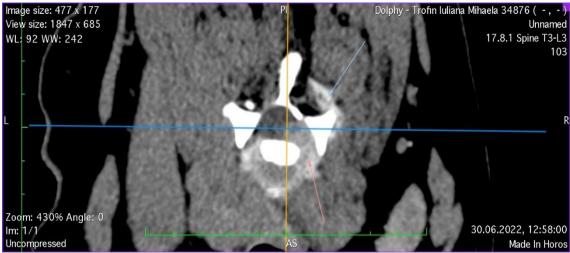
Transverse CT image- structure with neoformation character with invasion of the right side at C5-C6 level (arrows).
